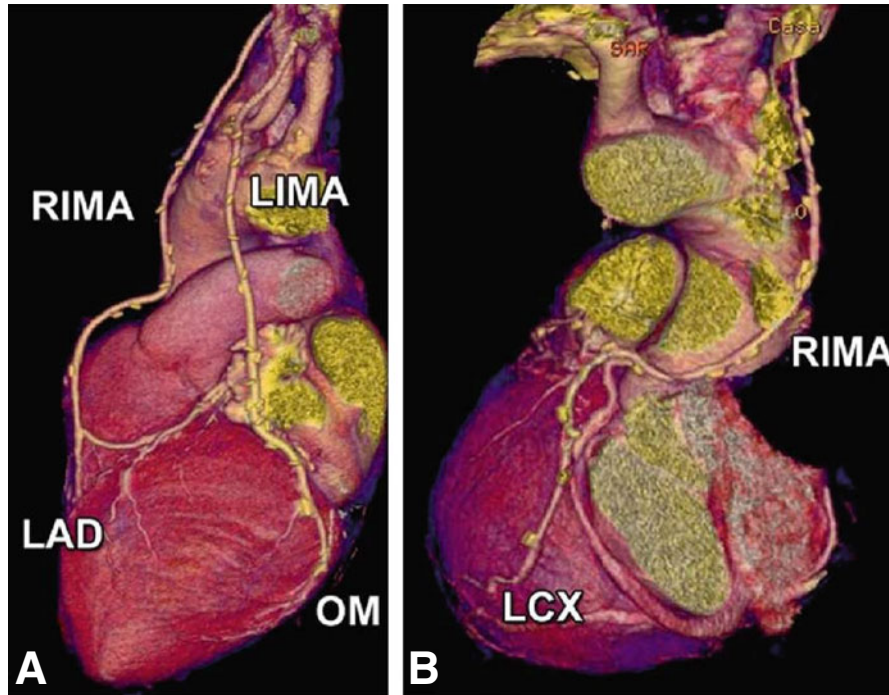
Different examples of left and right internal mammary artery grafts. Panel A shows three-dimensional reconstructions of the CT in a 68-year-old female patient who underwent left internal mammary artery (*LIMA*, skeletonized) grafting to an obtuse marginal branch (*OM*) and right internal mammary artery (*RIMA*, also skeletonized) to the left anterior descending coronary artery (*LAD*) 6 years ago. The CT was performed because of atypical angina and shows that both arteries are patent (volume-rendered three-dimensional reconstruction). Panel B shows a *RIMA* (skeletonized) anastomosed to the left circumflex coronary artery (*LCX*) across the transverse sinus behind the aorta in a 58-year-old male patient who was operated on 8 years ago. CT was performed because of an inconclusive stress test. The grafts were patent in both patients
